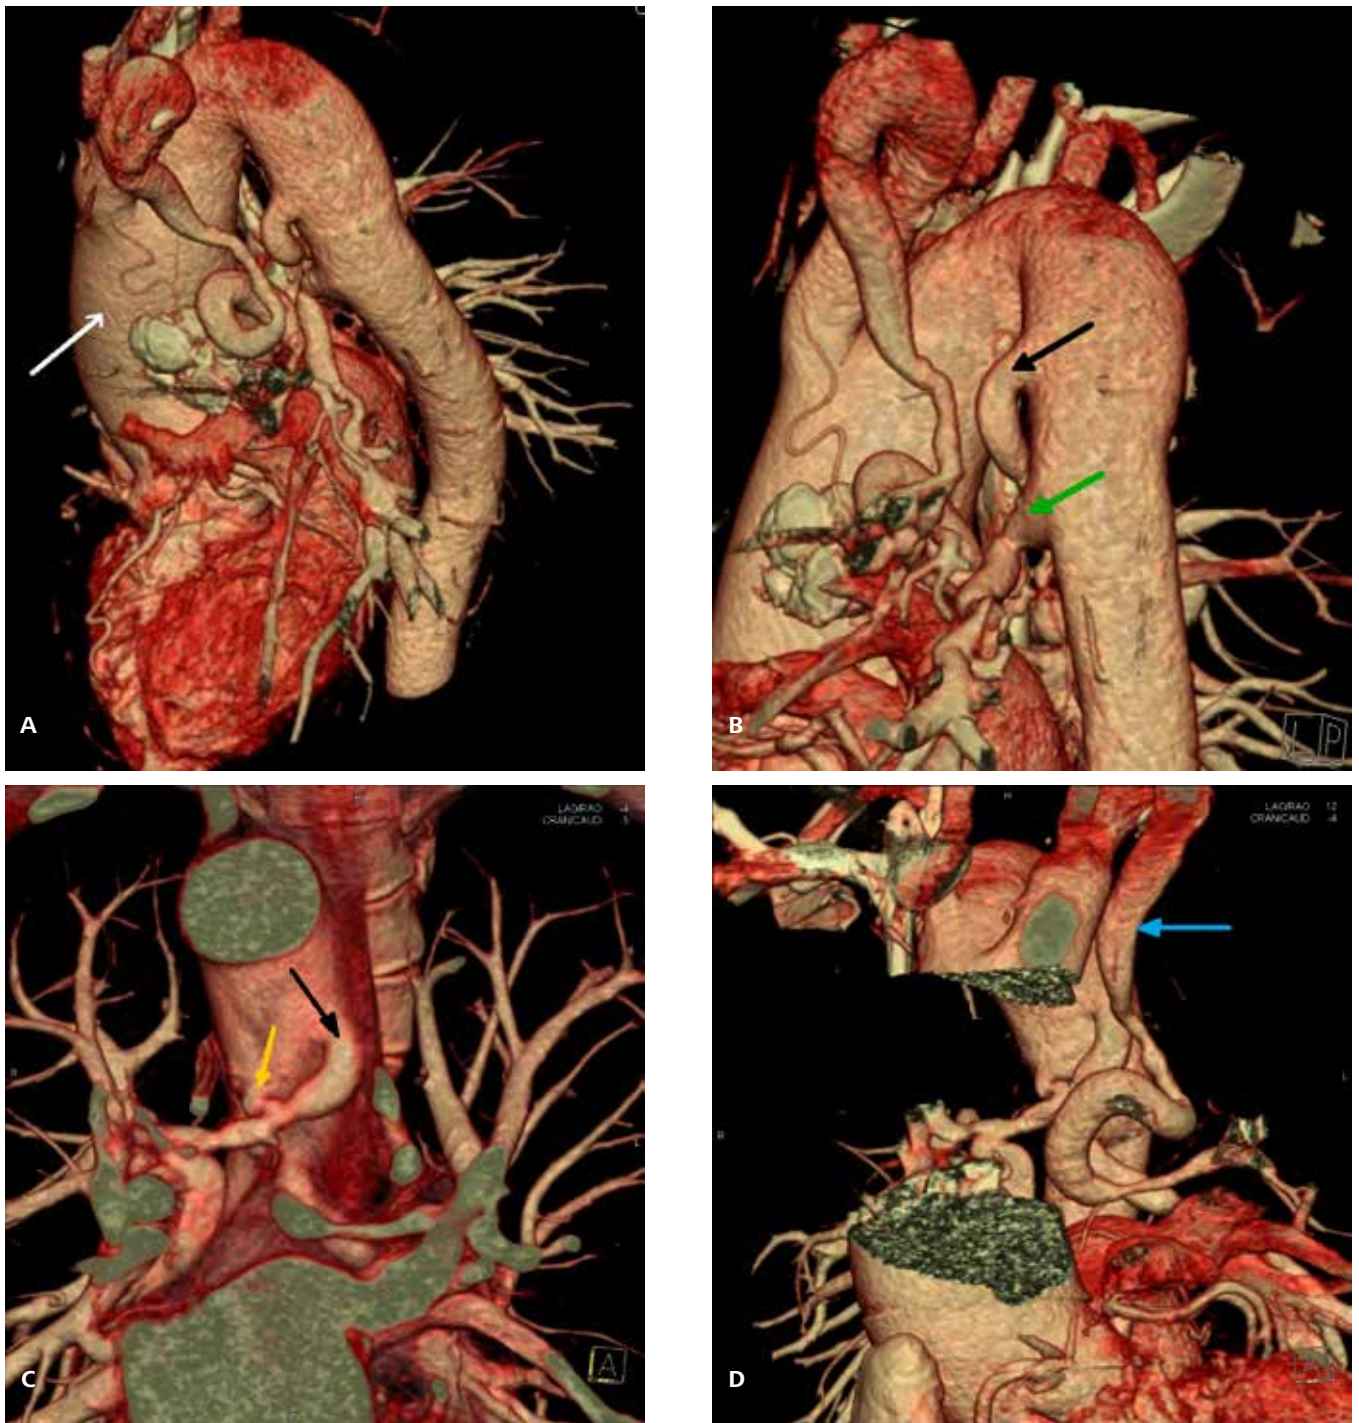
Computed tomography angiography of thoracic aorta. A. Right-sided aorta, ascending aorta dilated to 54 mm (white arrow). B, C, D. The anatomy of major aortopulmonary collaterals (MAPCAs). (MAPCA I – black arrow, MAPCA II – yellow arrow, MAPCA III – green arrow, MAPCA IV – blue arrow)
